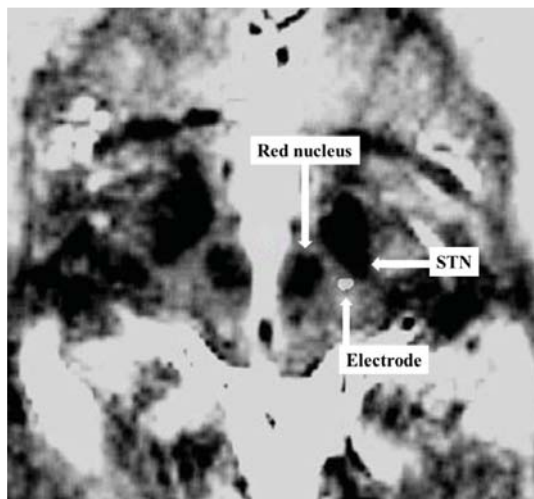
Preoperative T2-weighted MRI fused with a postoperative CT demonstrating the electrode in the left posterior subthalamic area. The image is at the level of the maximal diameter of the red nucleus.
